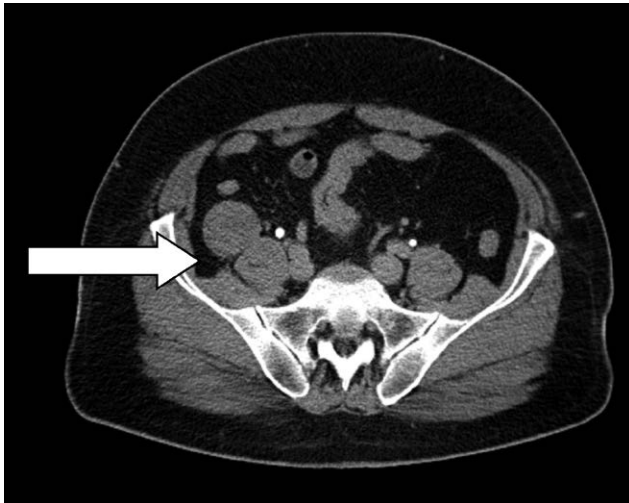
Axial CT image demonstrates a retroperitoneal mass of size 45 x 44 x 55 millimeters on the right side
